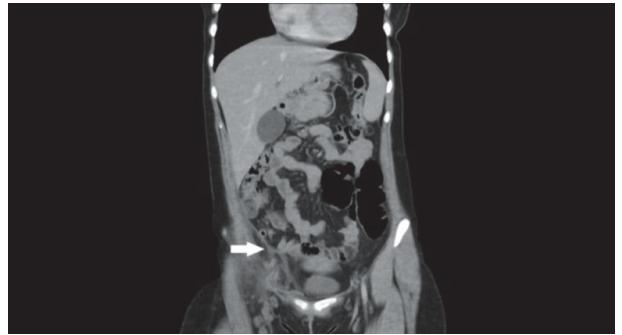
Elevated peritoneum due to perivascular oedema (arrow) was detected during a re-evaluation of computed tomography. Notice that a normal appendix vermis is adjacent to the elevated peritoneum.
